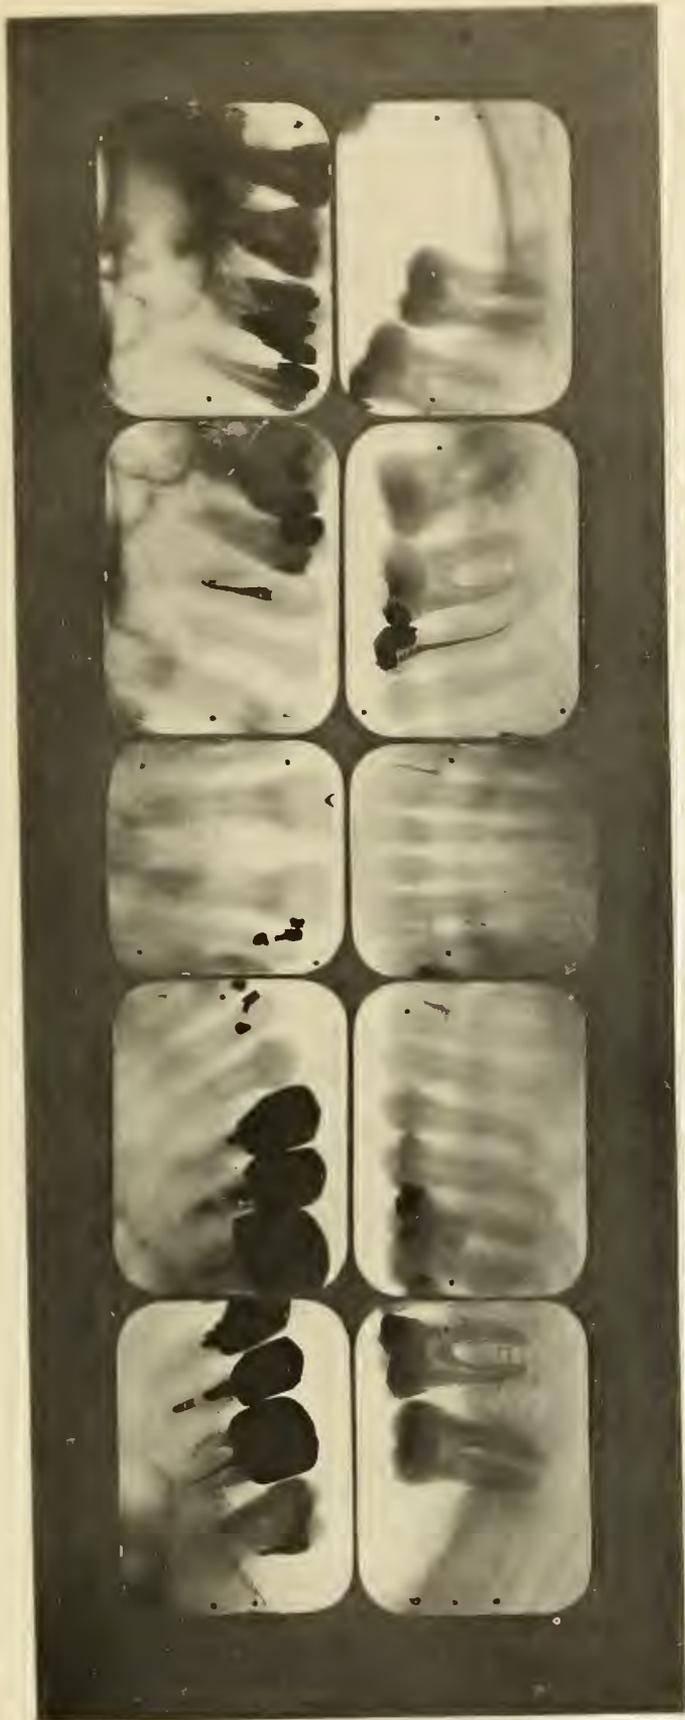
ROENTGENOGRAPHIC APPEARANCE OF TEETH OF PREVIOUS CASE, No. 1008.
